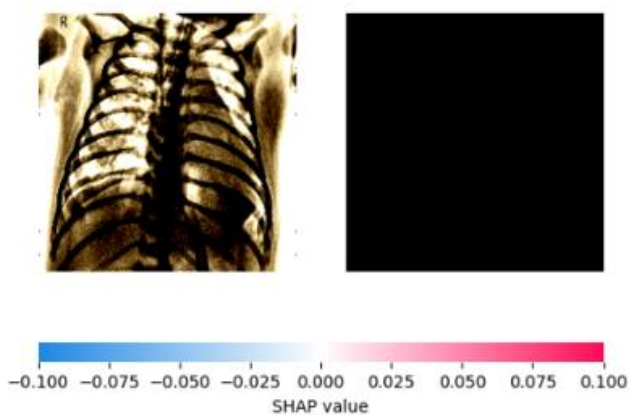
SHAP features value of a normal X-ray image for Nyangena Hospital
